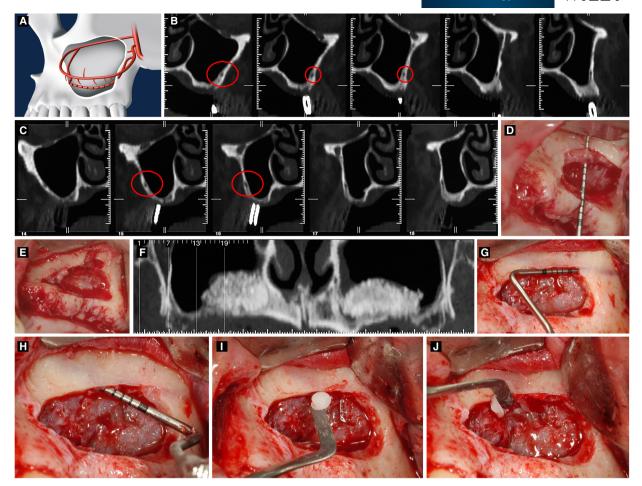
A, A vascular system that innervates the maxillary sinus vestibular wall. The infraorbital artery and the posterior superior alveolar artery form an intraosseous anastomosis (dotted line) as present in all cases and an extraosseous anastomosis as present in 40% of cases. (AAPS, posterior superior alveolar artery; AE, extraosseous anastomosis; AI, intraosseous anastomosis; AIO, infraorbital artery; AM, maxillary artery; Courtesy of Testori T. With permission Acme, Viterbo, Italy.) B, C, Preoperative computed tomography scan images. Bony canals (arrows) identified in the right and left lateral antral wall with close proximity to the alveolar ridge (Courtesy of Testori T. With permission Quintessence Publishing Co., Inc. Chicago, USA). D, Detection of the alveolar antral artery during left sinus floor augmentation; measuring nearly 3 mm in diameter (Courtesy of Testori T. With permission Quintessence Publishing Co., Inc. Chicago, USA). D, Detection of the alveolar antral artery during left sinus floor augmentation; measuring nearly 3 mm in diameter (Courtesy of Testori T. With permission Quintessence Publishing Co., Inc. Chicago, USA). E, Alveolar antral artery (arrows) after ligation (Courtesy of Testori T. With permission Quintessence Publishing Co., Inc. Chicago, USA). F, Postoperative computed tomography scan (panoramic view) following bilateral maxillary sinus floor augmentation (Courtesy of Testori T. With permission Acme, Viterbo, Italy). H, Mesial vascular trunk measurements taken with periodontal probe (Courtesy of Testori T. With permission Acme, Viterbo, Italy). I, J, Laceration to the intraosseous anastomosis incurs significant bleeding or hematomas postsurgically following clearance of vasoconstrictive local anesthetics. As such, bone wax can be locally applied to support hemostatic events. (Courtesy of Testori T. With permission Acme, Viterbo, Italy)
